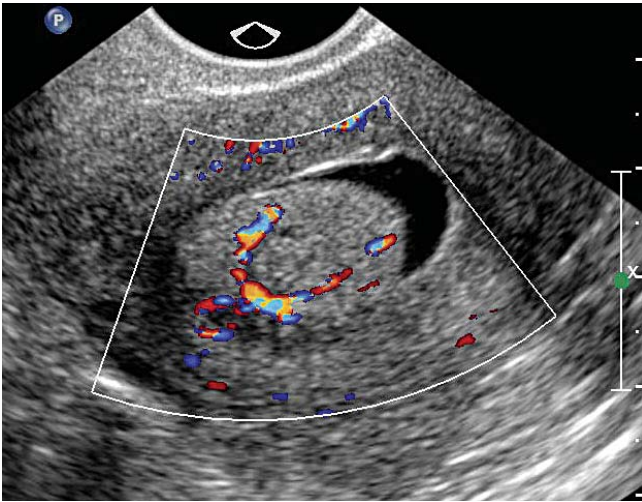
Smooth polyp with feeding vessel at hydrosonography.
